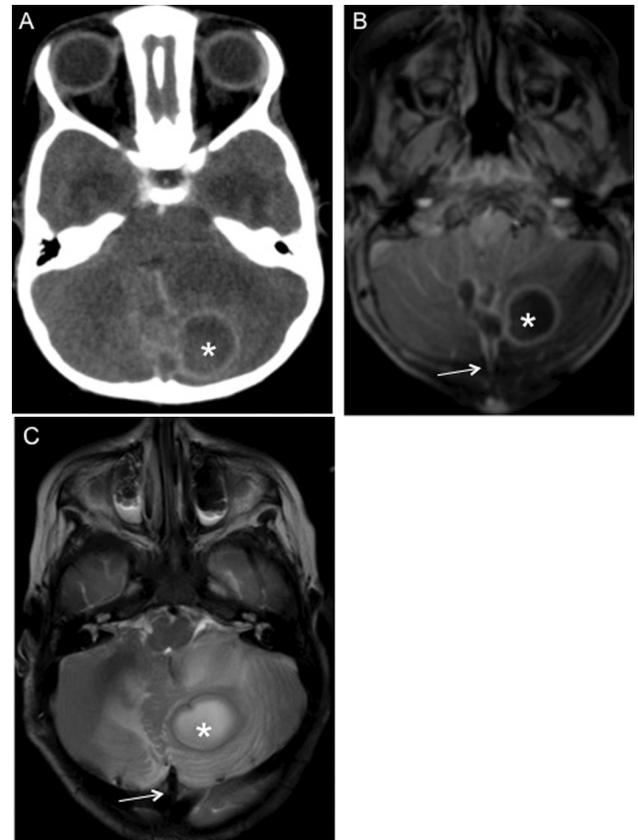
Cerebellar abscess in a child associated with a cranial dermal sinus. a Preoperative CT scan after contrast showing a left-hemisphere cerebellar abscess dislodging the brainstem and fourth ventricle (*) b Axial T₁-weighted after gadolinium and c axial T₂-weighted magnetic resonance (MR) images showing a space-occupying lesion (asterisks) associated with cerebellar edema and an occipital dermal sinus tract (arrows).
